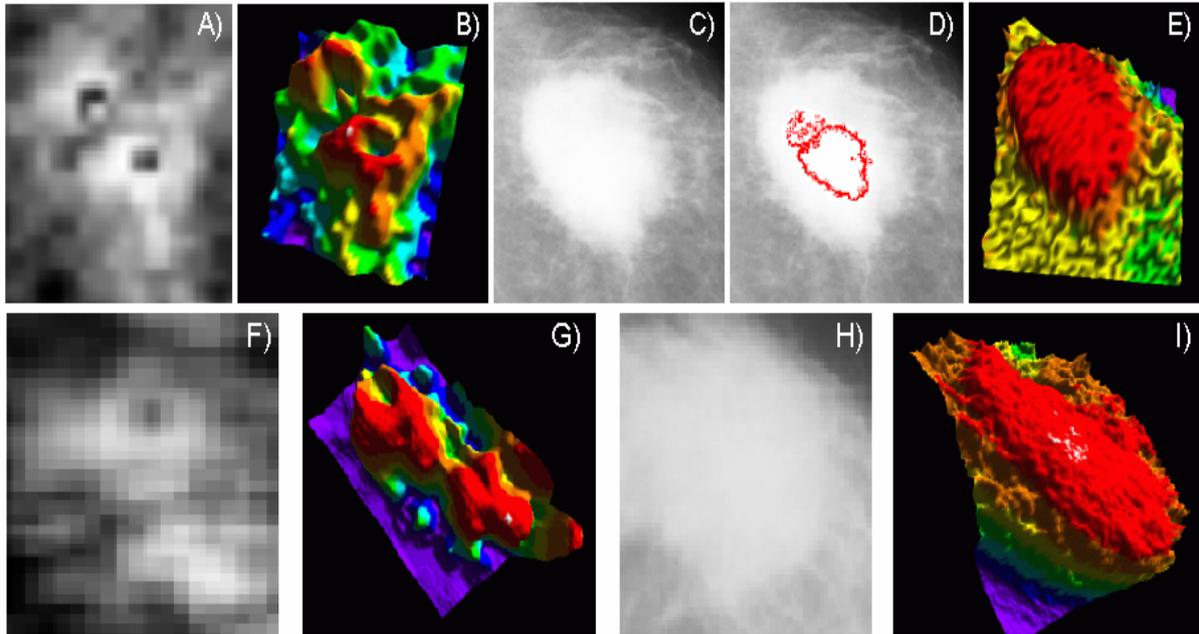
This figure shows two examples of large carcinomas that are poorly differentiated in the mammogram images (C, H). The corresponding registered MRI functional projections (A, F) provide additional information about vascularity and necrosis (visible as low-enhancement focal points). B) and G) show surface representations of the MRI projections to be compared with E) and I) which are the corresponding surface representations of tumours in the X-ray images. The first case is particularly interesting as the two necrotic regions can actually be correlated with structural information in the mammogram via some simple thresholding and edge detection D).
